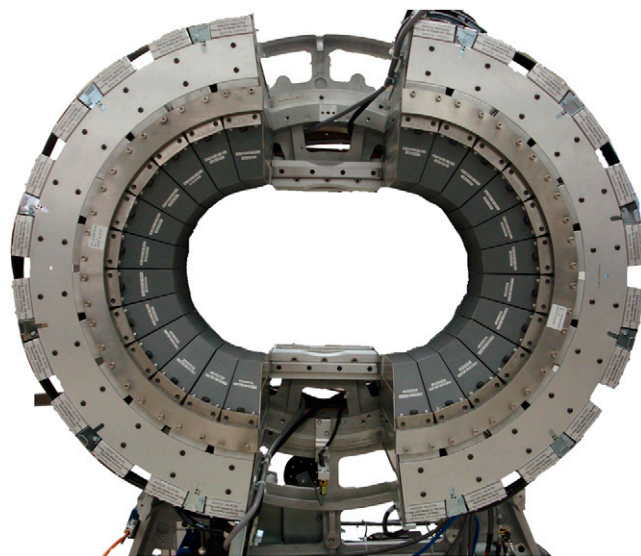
Neurologica's inSPira rotating and scanning SPECT brain camera. Internal workings with a total of 24 detector/focused-collimator units mounted on 2 semicircular (“clamshell”) gantry assemblies. (Courtesy Neurologica).
